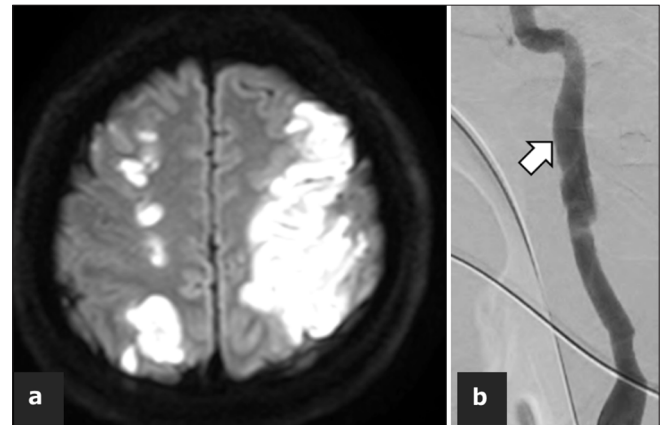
(a) Magnetic resonance imaging on the day after onset showed infarction in the right watershed region and left middle cerebral artery region. (b) Digital subtraction angiography showed the disappearance of a poorly contrasted area, which was suspected to represent a thrombus in the left internal carotid artery (arrow).
